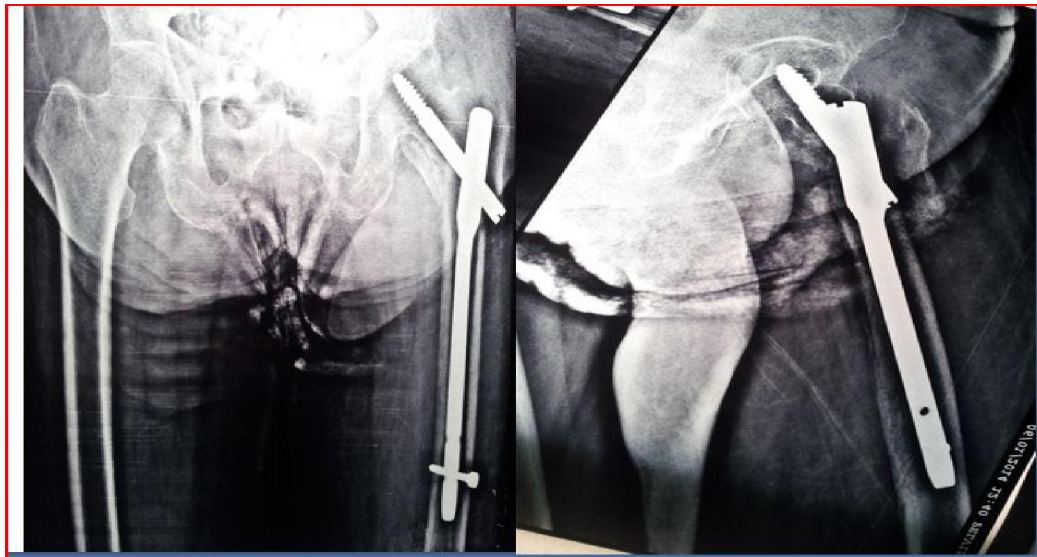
follow-up radiographsafter 3 monthsshowing good fracture union.
